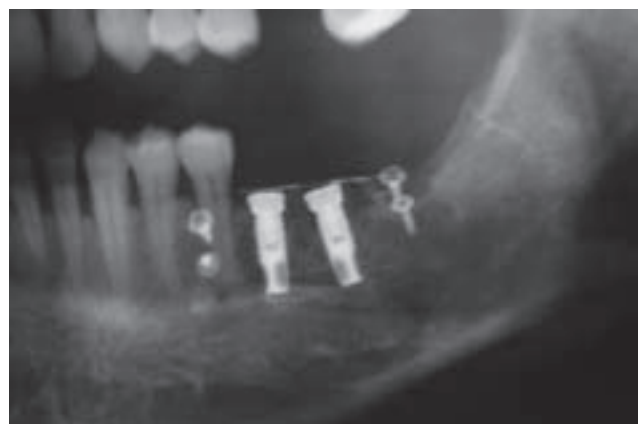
Orthopantomogram before membrane removal, showing the area regenerating by means of the guided bone regeneration technique.
